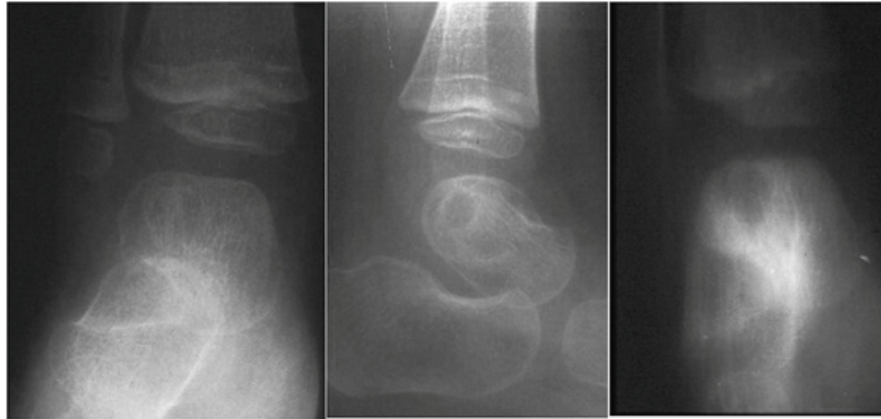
A 4-year-old boy with a 2-month history of ankle pain and limping. Imaging including radiographs and conventional tomography indicated a lytic lesion of the talus with a sclerotic rim.
